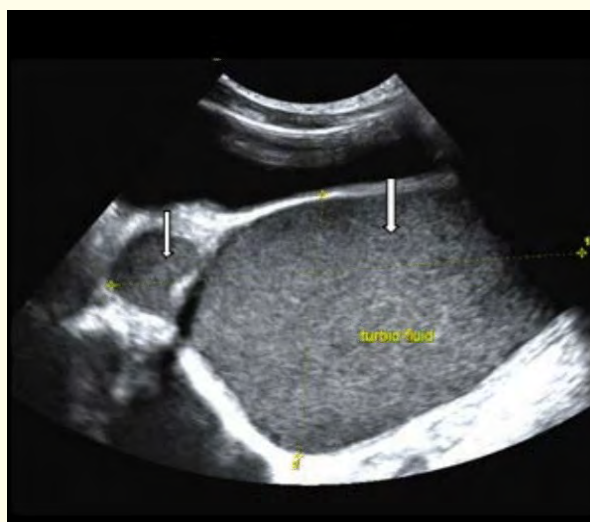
Ultrasound: Dilated vagina and cervix (arrows) filled with turbid fluid due to obstructed left hemivagina.
